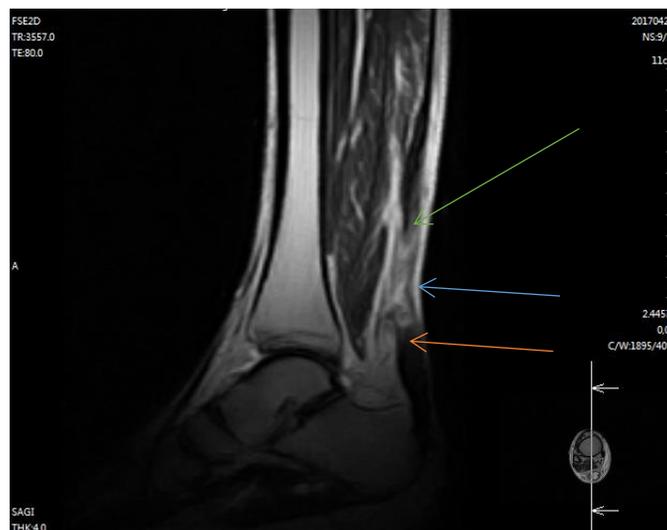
Sagittal T2W MRI of the right lower extremity image showing complete disruption of the Achilles tendon fibres, with a large gap filled with high signal oedema. Blue arrow showing the defect, red arrow showing the distal stump and orange arrow (proximal stump).
